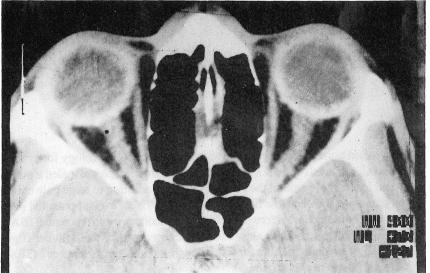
CT scan of the orbit showing irregular thickening of the optic nerves.
